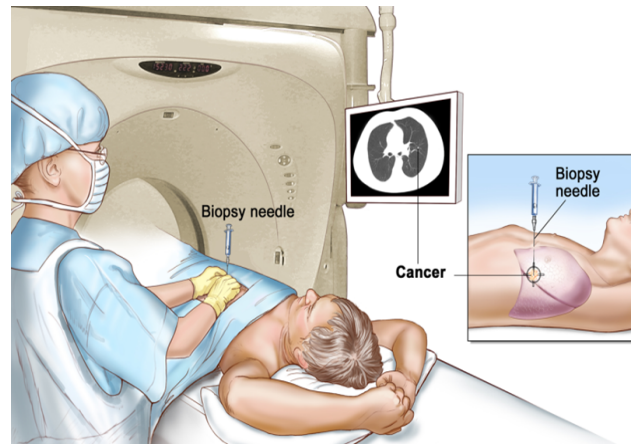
Manual biopsy of lung cancer using CT images [22].
